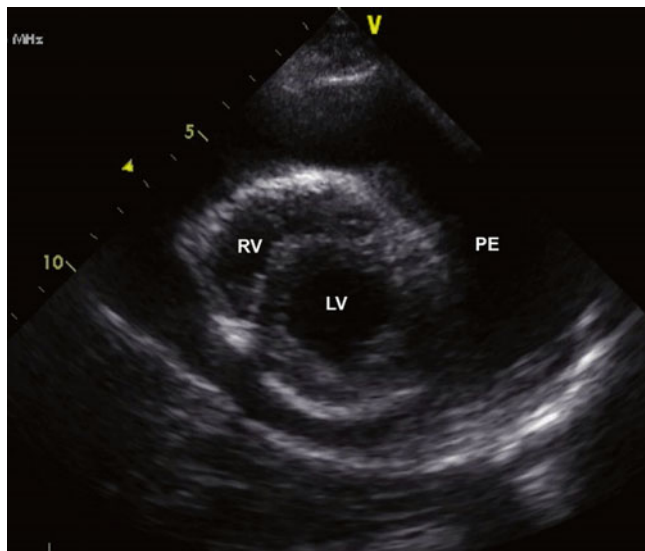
Parasternal short axis view of the heart on echocardiogram demonstrating a circumferential pericardial effusion. PE pericardial effusion, RV right ventricle, LV left ventricle
